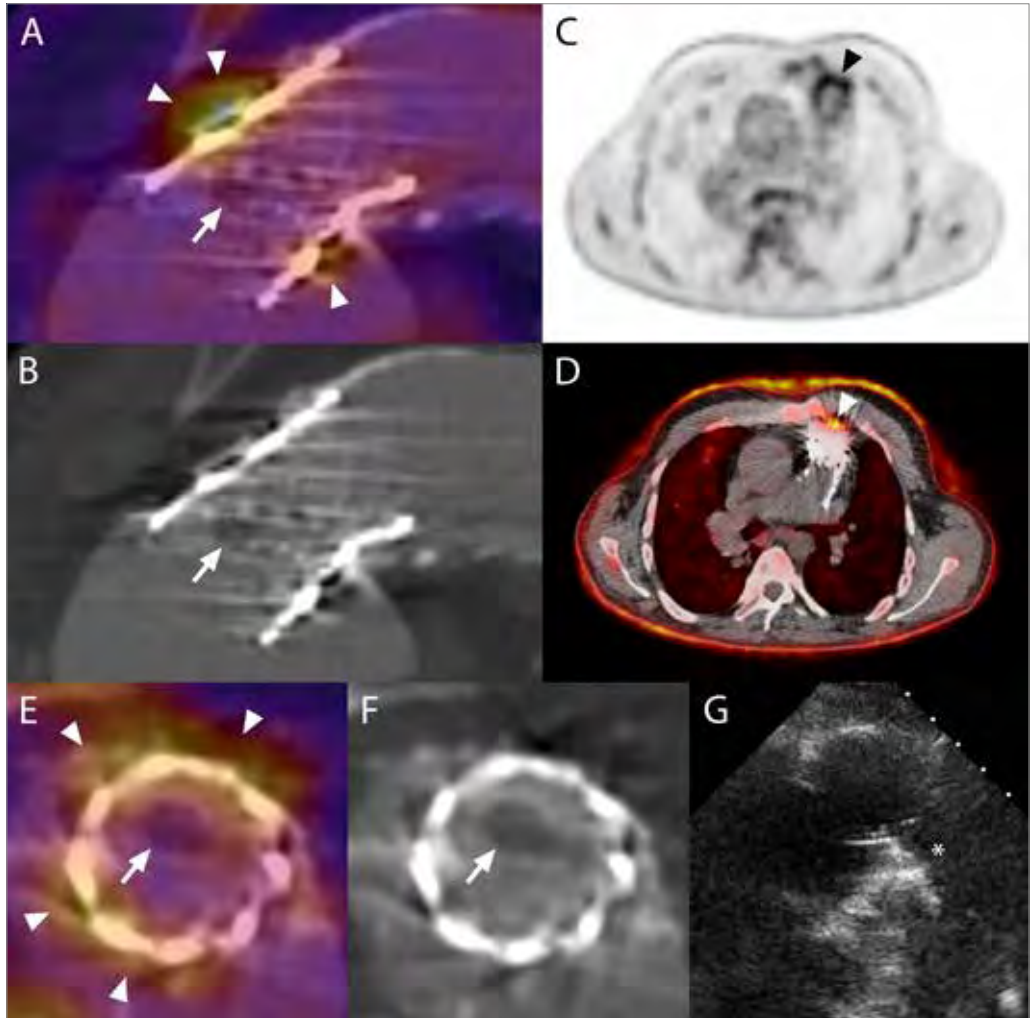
Fused PET/CTA (A, C) and CTA (B, F) long- and short-axis images of the Melody pulmonary valve prosthesis, showing multifocal intense FDG uptake surrounding the mid-section of the prosthesis (arrowheads) as well as a vegetation on one of the valve leaflets (arrow), which was missed on echo (G). (C, D) Conventional non-attenuation-corrected (NAC) PET and PET/CT images. (*) Melody valve prosthesis.
